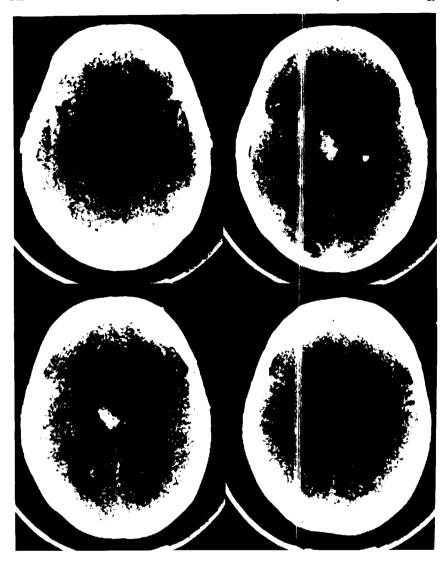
Computed tomographic scan. The 4 consecutive slices show a haematoma in the medial aspect of the right thalamus and the genu of the right internal capsule, measuring 2.2 cm anteroposteriorly, 1.4 cm transversely and 3 cm cephalocaudally. There is a small amount of blood in the third ventricle and possibly in the medial aspect of the left thalamus.
